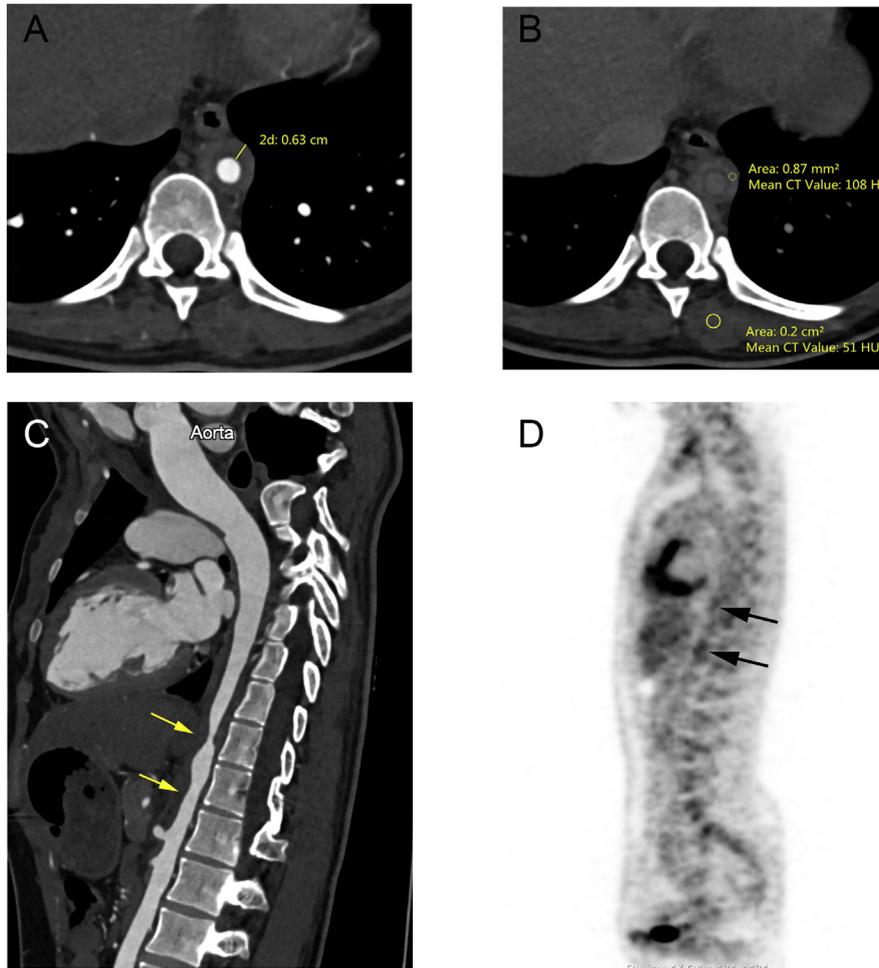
Representative case #1 (an active Takayasu arteritis). An 18-year-old female complained of a lower limb claudication and hypertension for 3 months. The CRP and ESR were normal, 2.29 mg/dl and 12 mm/h, respectively. CTA axial images showed maximal wall thickness was 6.3 mm, relative post-contrast enhancement ratio was 2.1 and an active Takayasu arteritis was diagnosed by CTA (A, B). Curved planar reformation showed stenosis in the thoracic artery (C). 18F-fluorodeoxyglucose-PET showed abnormal uptake in the diseased thoracic artery (D).
